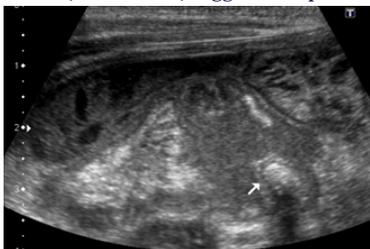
Transverse sonogram in a patient with appendicular perforation reveals an echogenic appendicolith (white arrow). Surrounding fluid with internal echoes is noted.
